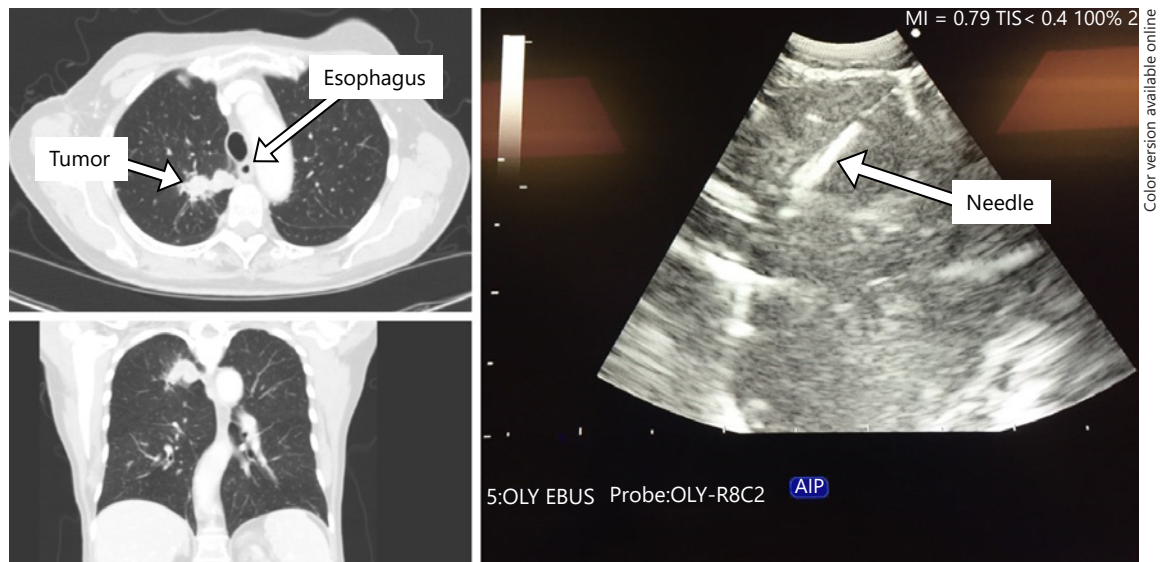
CT scan and EUS-B picture from a 77-year-old woman admitted with a 30-mm lesion in the right upper lobe. The tumor could not be visualized by bronchoscopy or EBUS. EUS-B-FNA from the lesion showed pulmonary adenocarcinoma. The distance
